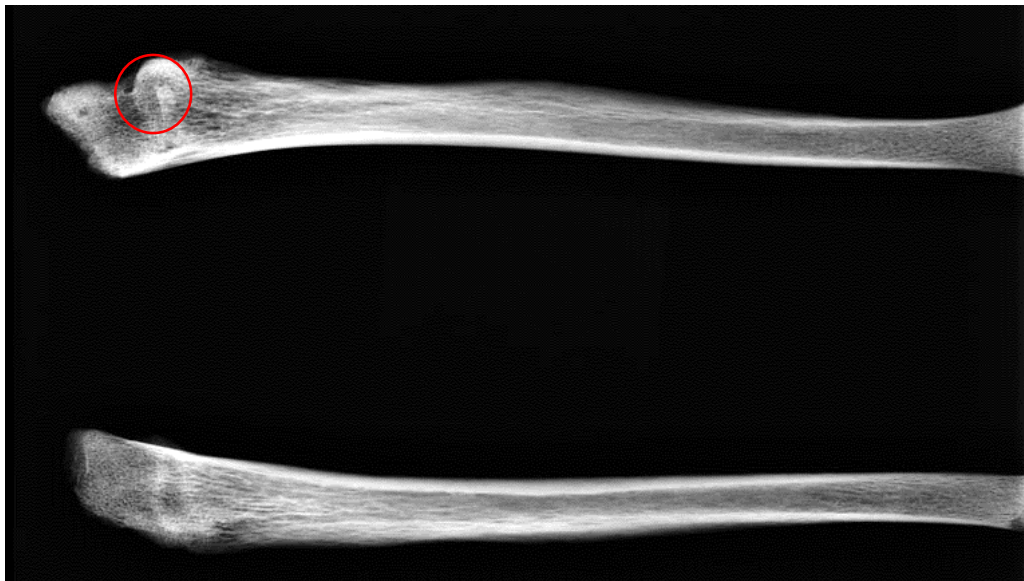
Anterior radiograph of left (top) and right ulna. No fracture line is evident in the proximal left ulna but an area of increased cortical density at the coronoid process. From Bath Gate, Cirencester, skeleton 299. (with permission from Corinium Museum)
